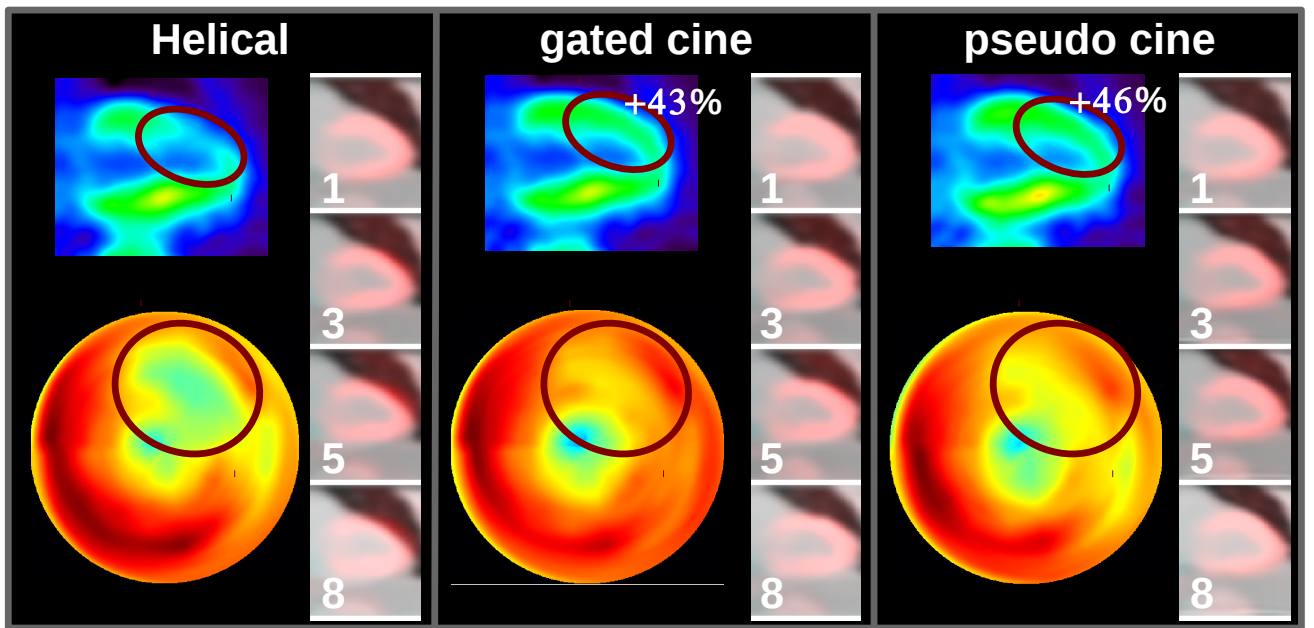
An example where PET-CT alignment improved from 7.9 mm with the helical CT to 3.0 mm and 0.6 mm for the gated and pseudo gated CTs respectively. Anterior apical defect on the AC_{HCT} PET images is not present in AC_{GCT} and AC_{pseudo} , and the anterior wall increased by 43% and 46% respectively.
